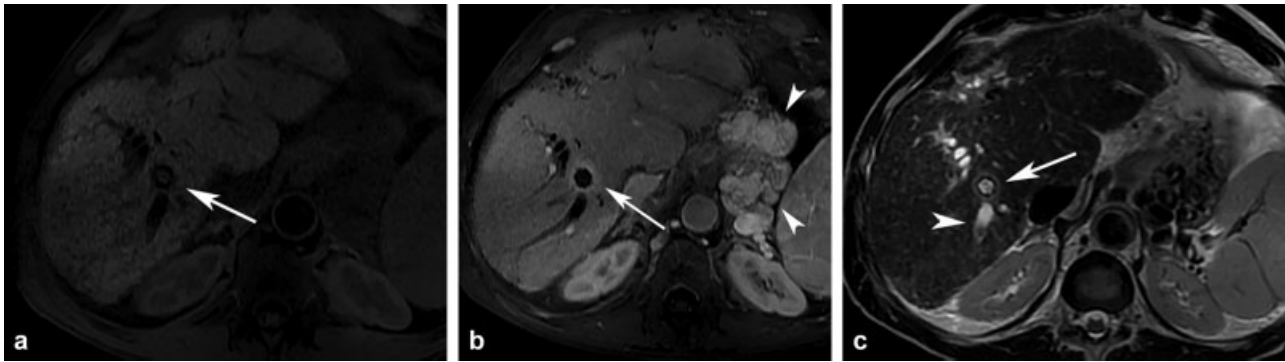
Axial MR images of a 65-year-old man with history of OLT, with recurrent hepatitis B virus cirrhosis and TIPS creation 4 years earlier for variceal bleeding, admitted for cholangitis. An irregular T1-hypointense rim (*arrow*) adjacent to the TIPS is present on T1-weighted images with fat saturation (a) with corresponding peri-TIPS hyperenhancement (*arrow*) after administration of gadolinium contrast (b) and nonenhancement of the occluded lumen. Enhancing gastric varices are also present (*arrowheads*). T2-weighted images with fat saturation (c) demonstrate a corresponding irregular halo of T2 prolongation (*arrow*) adjacent to the TIPS; moderate intrahepatic biliary ductal dilation is also noted (*arrowhead*). In retrospect, peri-TIPS T2 prolongation and enhancement in the setting of TIPS occlusion and cholangitis is suggestive of endotipsitis.
